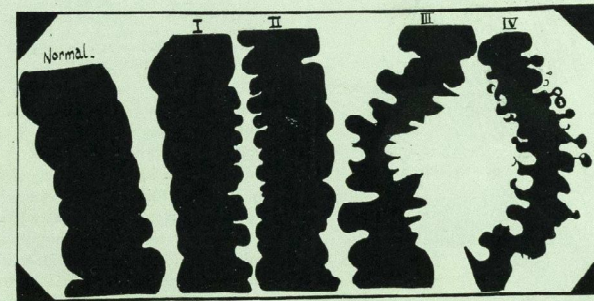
Direct tracings from X-ray photographs, contrasting the normal outline with I and II, early irregularity; III, the "saw-tooth" edge; IV, fully formed diverticula with several concretions. (One half natural size.)
